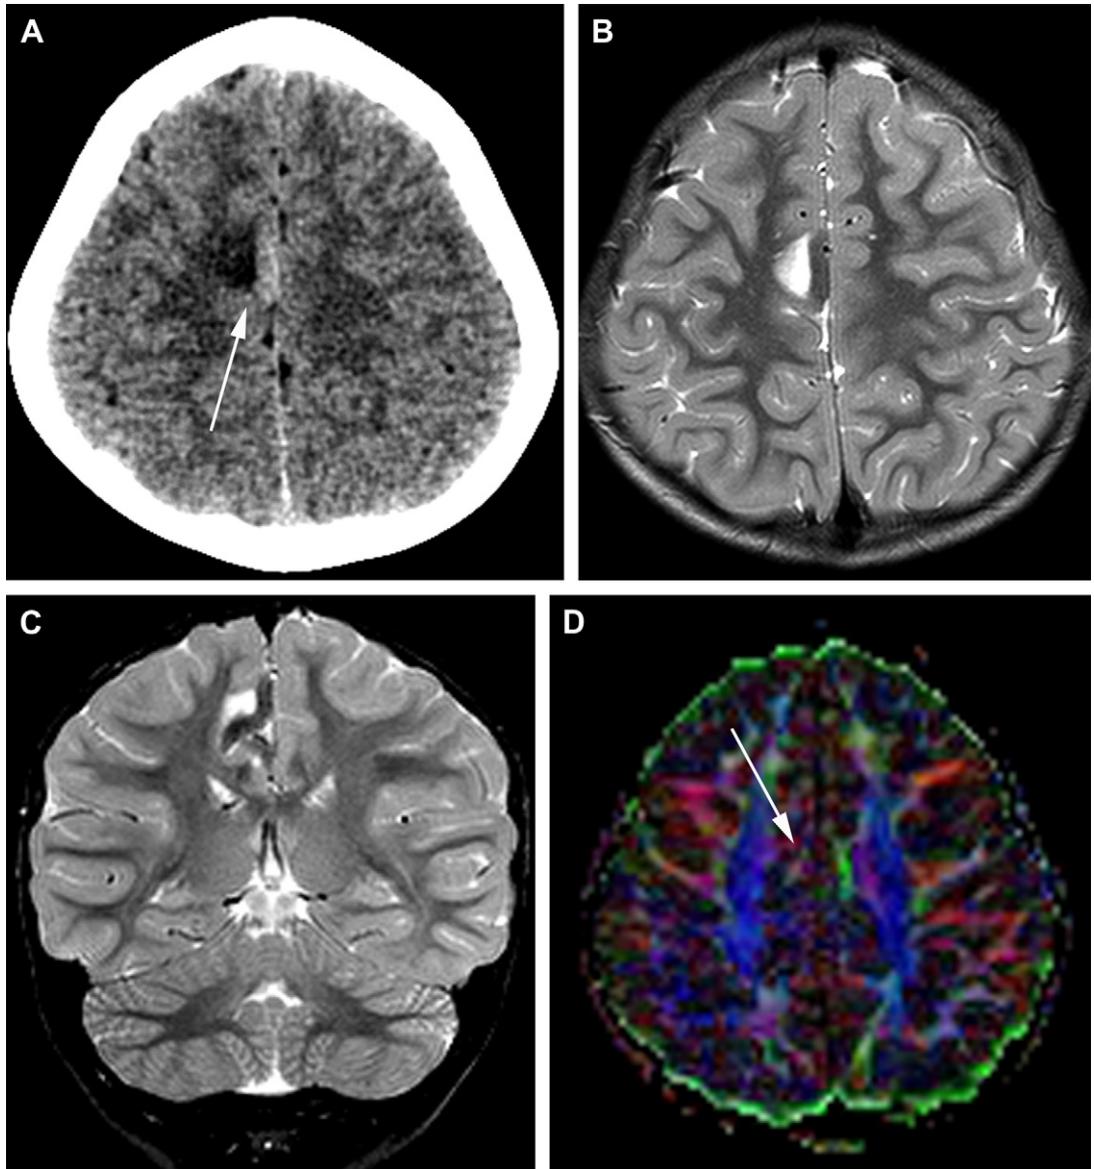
FCD IIIc. Meningoangiomas. (A) Unenhanced CT. Small focal area of low attenuation with adjacent dense, likely calcified medial frontal cortex (*arrow*). (B) Axial T2. Demonstration of the corresponding MR image, with low signal of the calcified cortex and bright signal of the white matter. (C) Coronal T2. The lesion affects both the superior frontal and the cingulate gyri. (D) FA color mapping. The lack of parasagittal fibers of the cingulum in the lesion is demonstrated (*arrow*).
